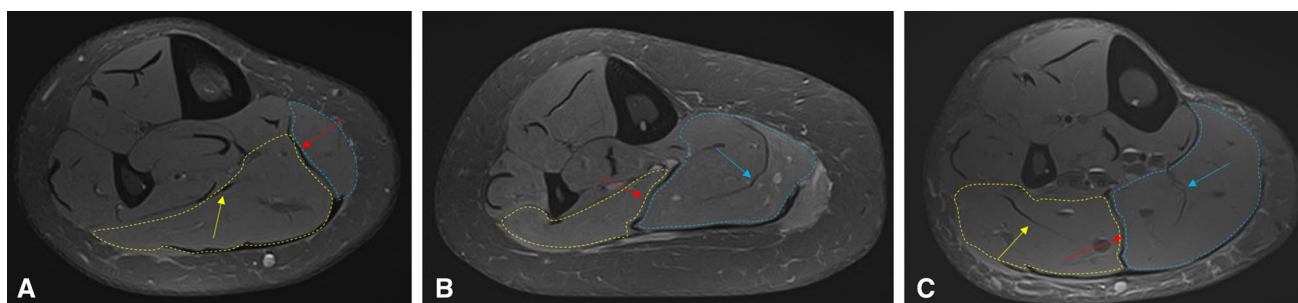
MRI AX T2W FS as an example of different dominance types. The dotted yellow line indicates the lateral muscle volume of the soleus muscle and the dotted blue line the medial muscle volume. A Soleus muscle with a lateral muscle dominance and a lateral connective
